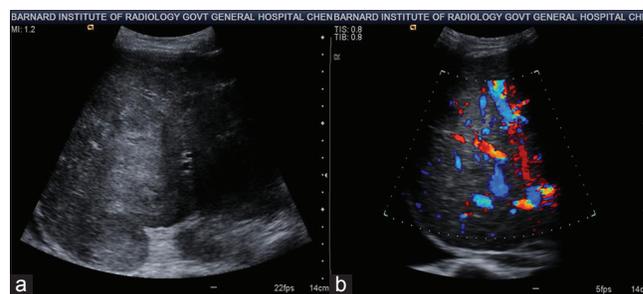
(a and b) Conventional gray-scale ultrasonography - large heteroechoic lesion in right lobe of the liver with high vascularity. Hypervascular metastasis
